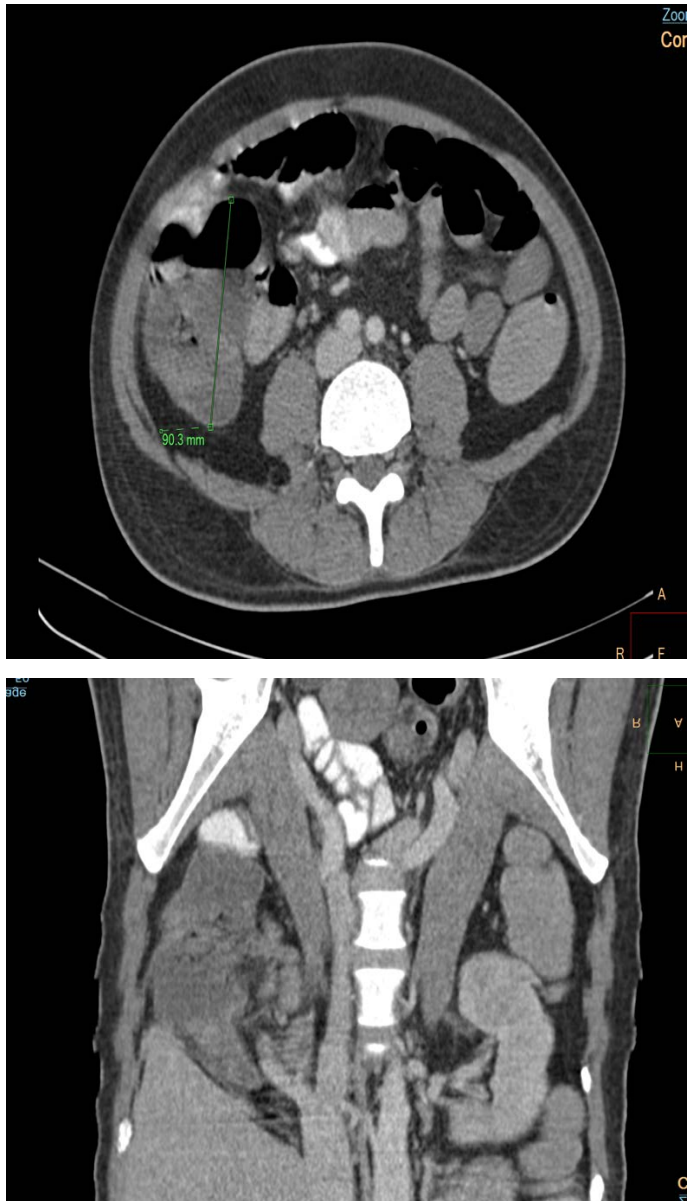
Abdominal CT scan (cross-section and frontal) showing distended cecum and circumferential wall thickening
